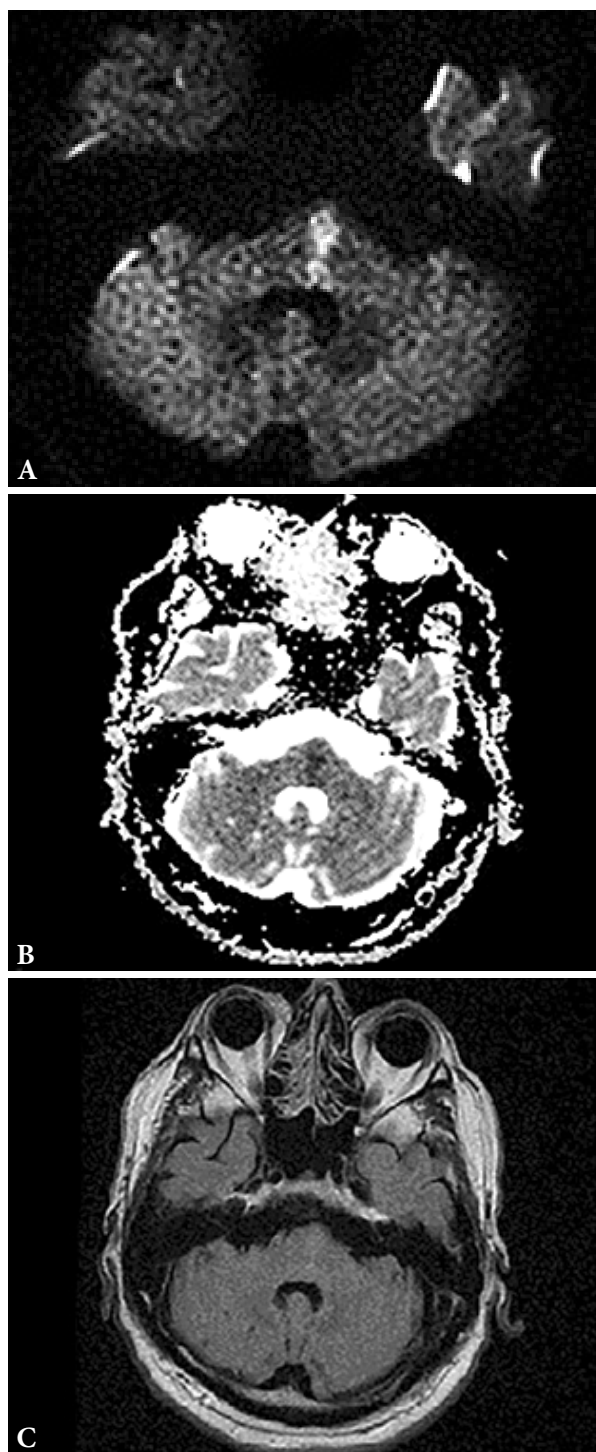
DWI-FLAIR mismatch: A) DWI signal hyperintensity in the left side of pons; B) Apparent diffusion coefficient map with a corresponding hypointense pontine zone; C) FLAIR without a hyperintense signal in the pons region
